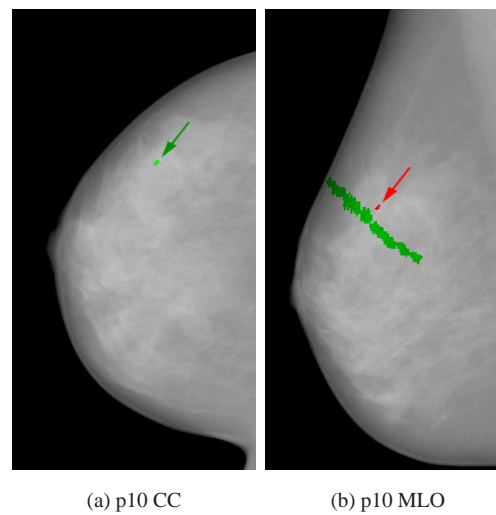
CC to MLO registration results for patient p10. The clip on the CC view its projection on the MLO are shown in green. The X-ray clip on the MLO view is shown in red. The error is $5.1mm$.
